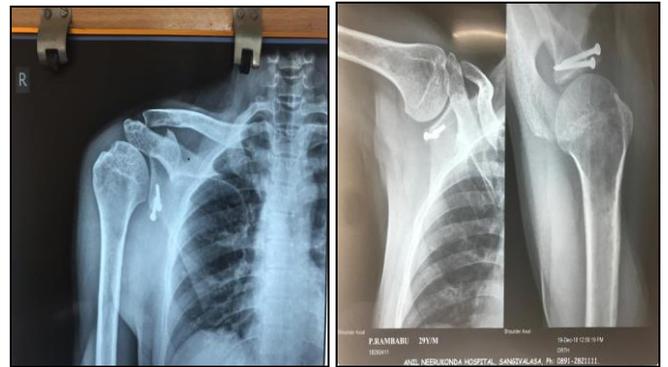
Post Op xrays at final follow Up
